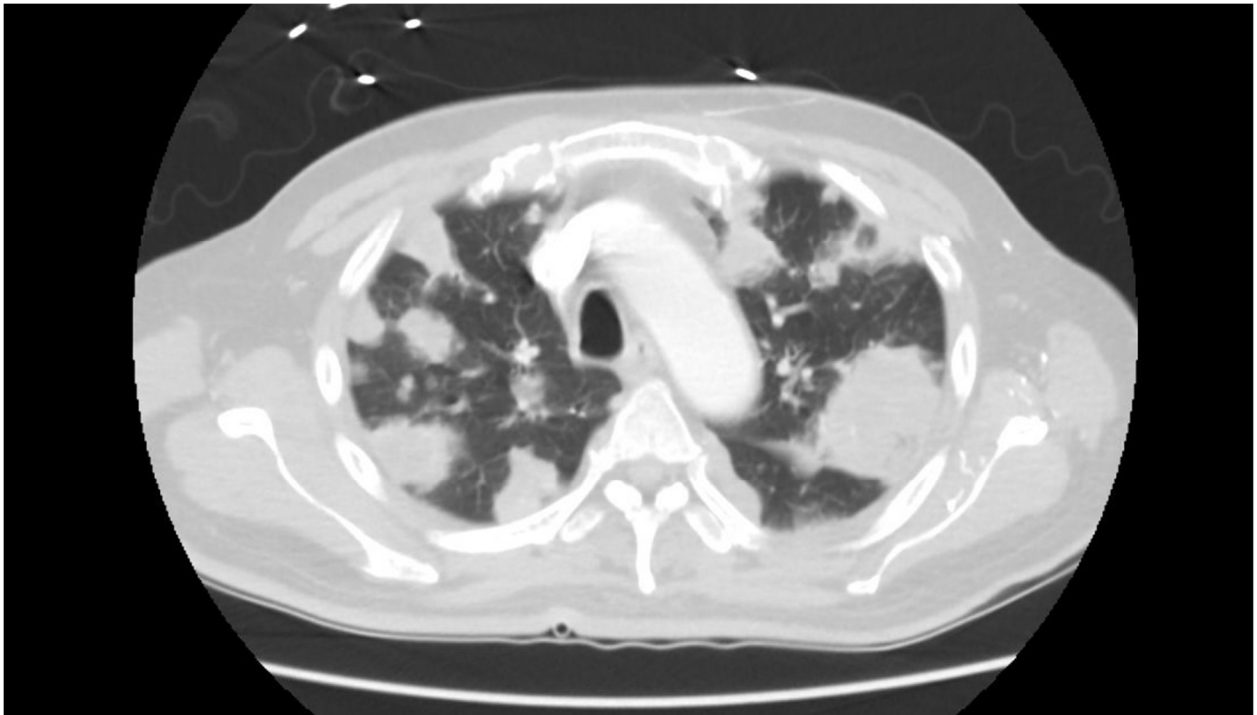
Coronal cut of CT (Computed Tomography) chest showing multiple rounded masses and consolidations
